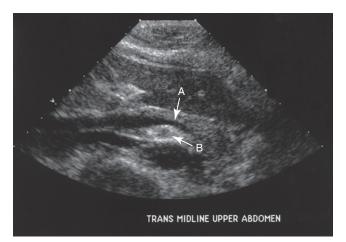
Transverse sonogram of the upper abdomen.
